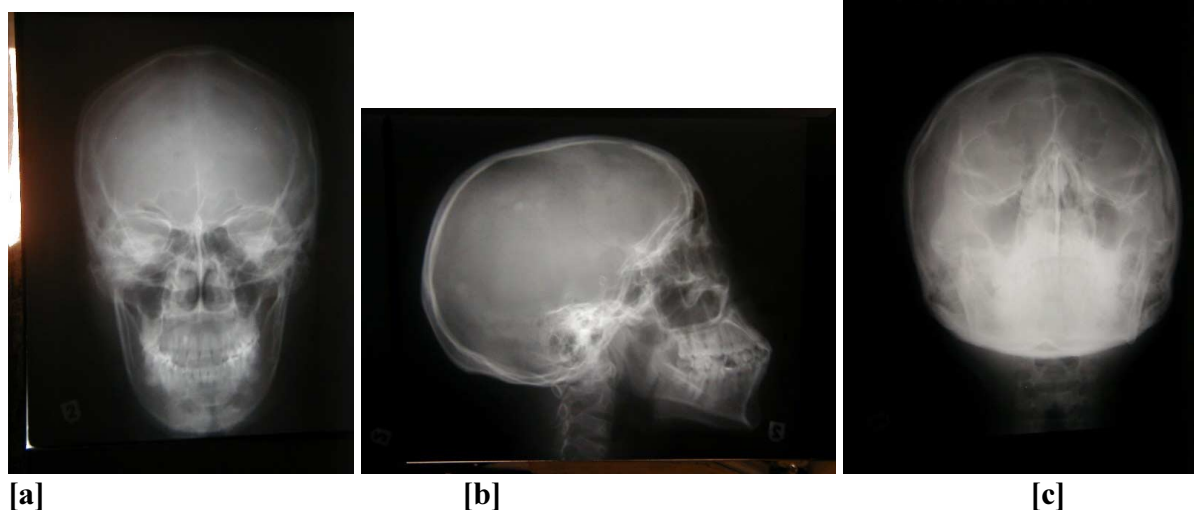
X-ray radiography at SID 125 centimeters: [a] skull postero-anterior view; [b] skull lateral view; [c] Paranasal sinuses (Blondeau view).
